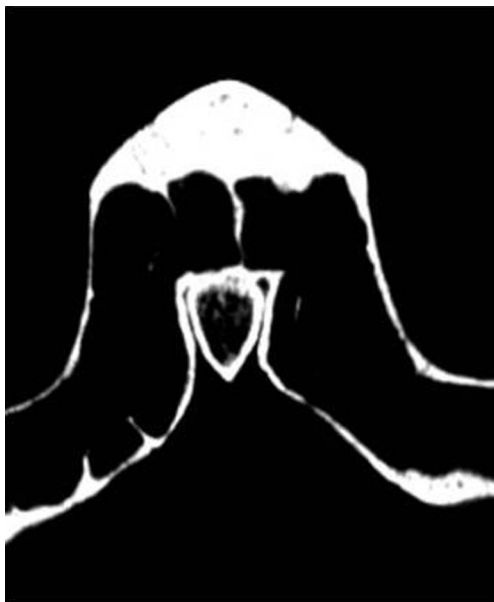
Coronal CT scan of the human skull showing a large cavity within the crista galli. Maximall width and hight could be measured in this projection. This type of pneumatization corresponds well to Keros type B, Hajjiannou’s type 1 and proportion type M
